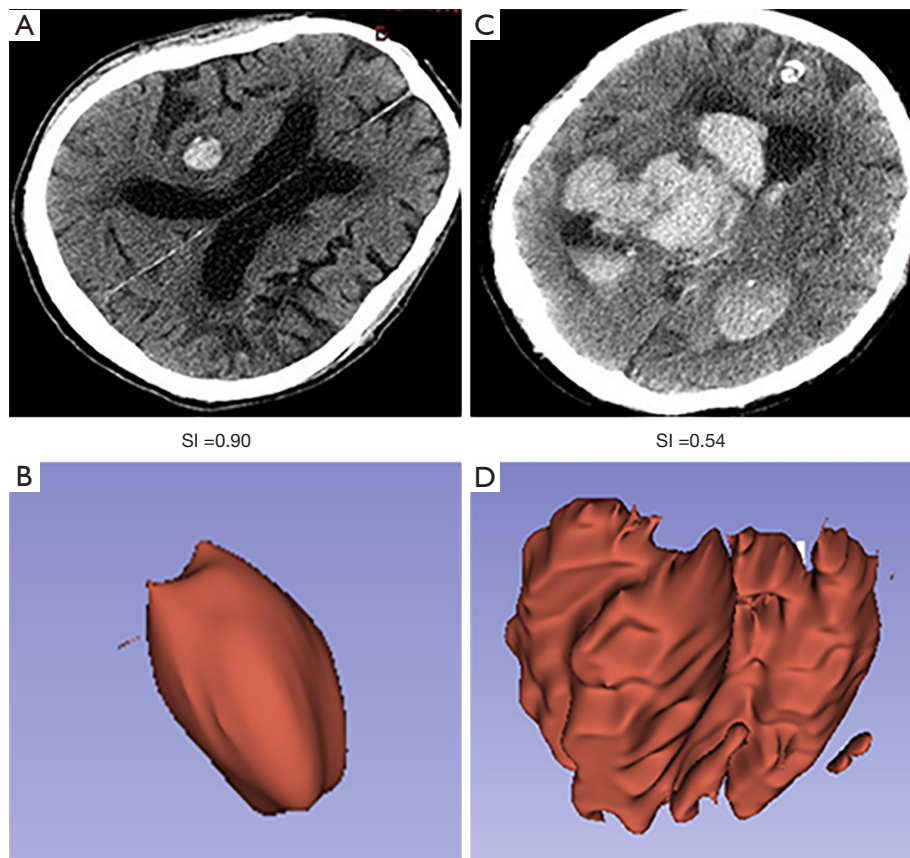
Axial CT images and 3D models with corresponding SI values of 2 patients with ICH. (A,B) Axial CT image and 3D model of a patient with ICH and a regular hematoma shape. (C,D) Axial CT image and 3D model of a patient with ICH and an irregular hematoma shape. 3D, three-dimensional; CT, computed tomography; SI, sphericity index; ICH, intracerebral hemorrhage.
